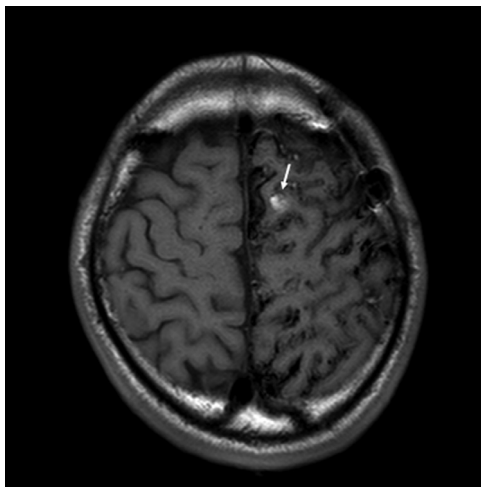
Axial T1-weighted images at 2 years after indirect revascularization in 2015. A small intracerebral hemorrhage was found in left frontal lobe (arrow).
